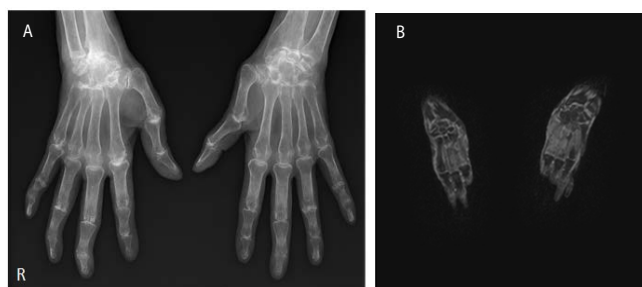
Imaging studies of case. 1a) Plain radiograph of the hands revealed erosion, joint space narrowing and bony ankylosis at the carpal joint, as well as erosion and joint space narrowing at the metacarpophalangeal joints and the proximal interphalangeal joints. 1b) Gadolinium-enhanced MRI revealed no signs of active synovitis or bone marrow edema at bilateral wrist joints.
